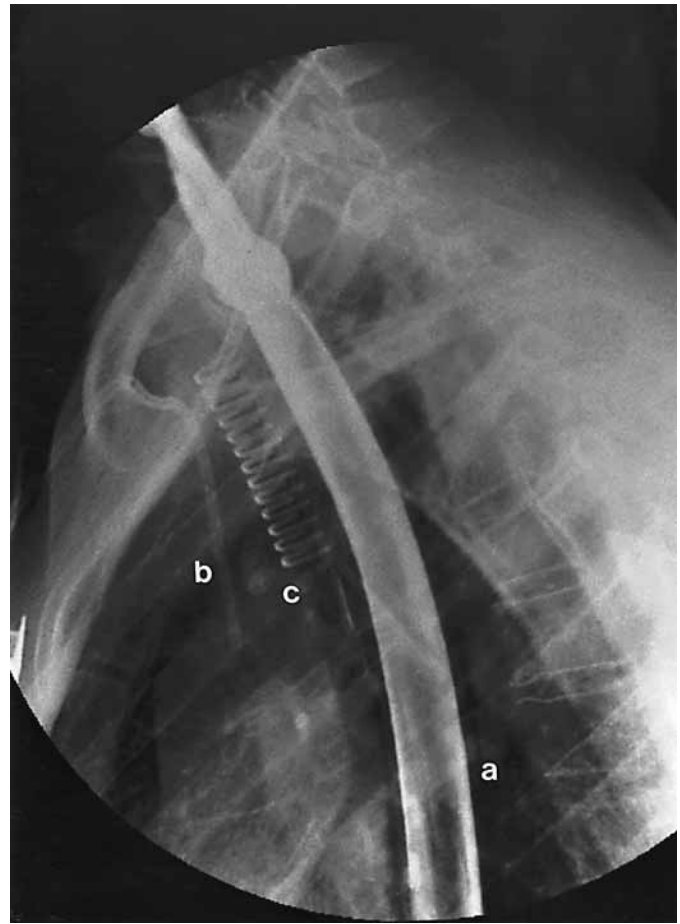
Lateral thorax X-ray with Montgomery stent in projection on esophagus (a). Good contrast medium passage, no leakage visible. Dynamic stent in projection on trachea (c) and central venous port (b).
